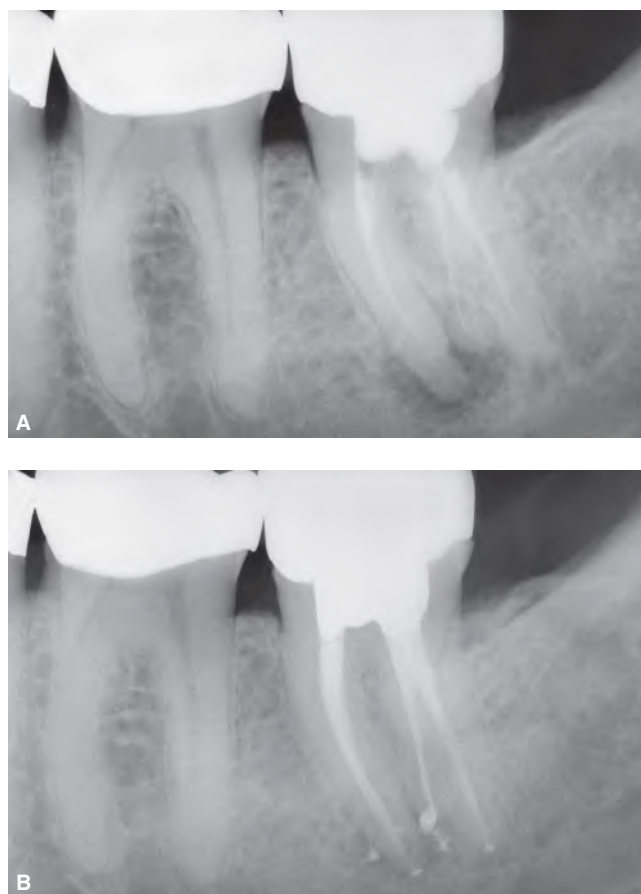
A. Preoperative radiograph of a failing endodontic treatment with a paste canal filling in a mandibular left second molar. Note the extra DL root. B. Five-year recall radiograph showing the treatment of multiple apical portals of exit and excellent osseous healing.
